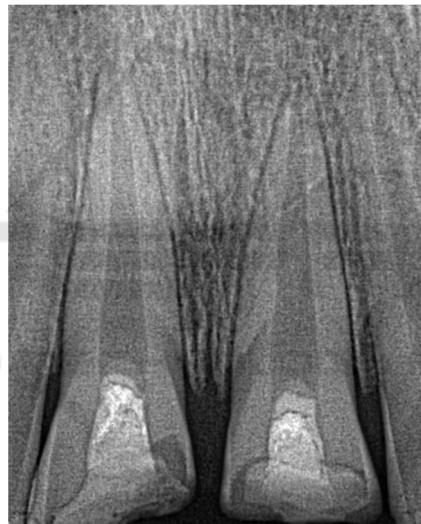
The preoperative periapical radiograph of tooth 11 and 21 with open apex.
